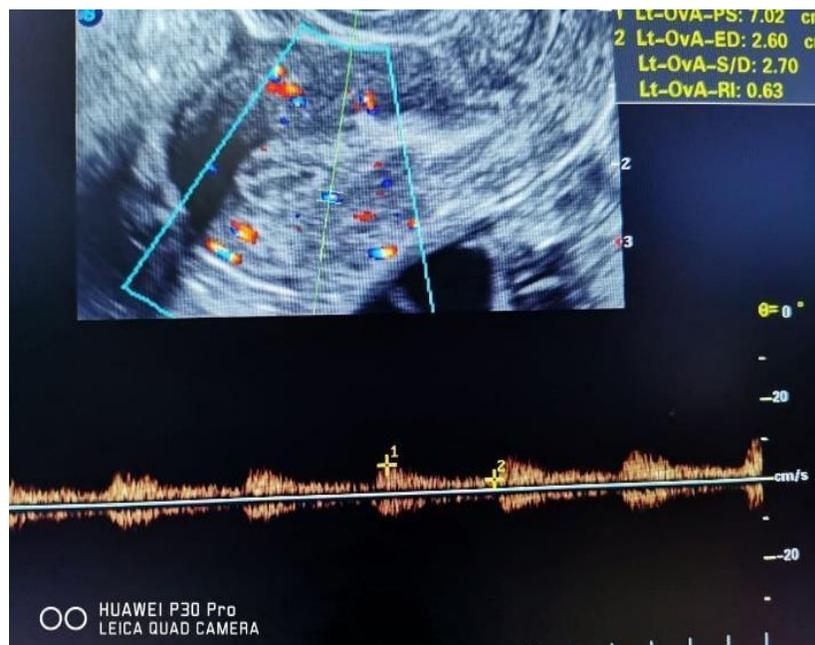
Sub endometrial blood vessels Color Doppler ultrasound velocimetry with pulsed type in a case of good receptive endometrium (High Institute of Infertility Diagnosis and ARTs /Al-Nahrain University, IRAQ, Baghdad).
